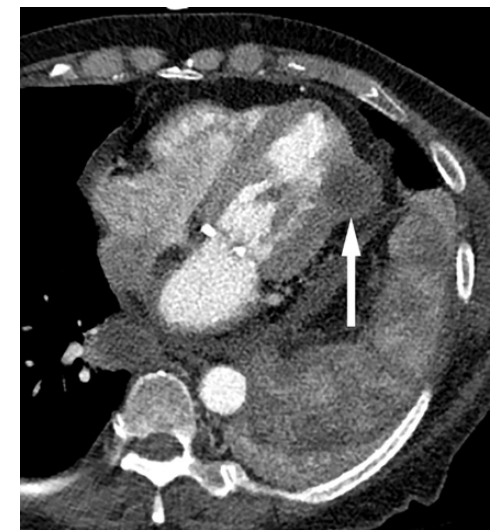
Contrast-enhanced image from a Chest CT demonstrates a hypodense lesion arising from the left ventricular lateral wall myocardium. Low attenuation in the center suggests necrosis.
